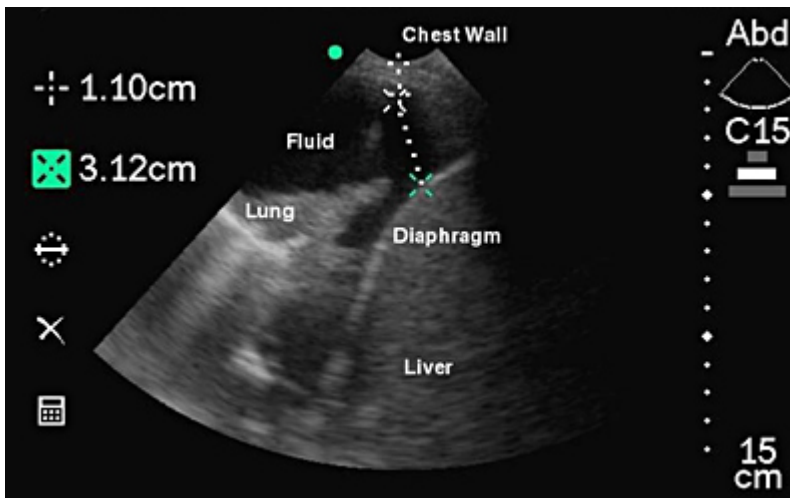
Ultrasound image directed from the right lower chest wall toward the lung. Pleural fluid is shown as a dark, anechoic region. Atelectatic lung is shown contrasted as a white density. The diaphragm (white curved structure) and liver are within reach of a thoracentesis needle (potential needle path shown by dotted line).
